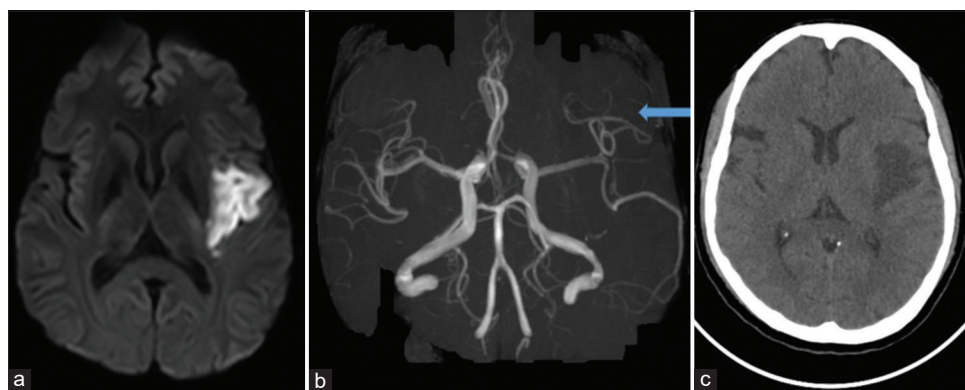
Panel a: DWMRI axial sequence showing left MCA opercular infarction. Panel b: MRA shows left MCA branch occlusion (blue arrow). Panel c: CT brain at 24 h showing completed left MCA opercular infarction without hemorrhagic transformation
